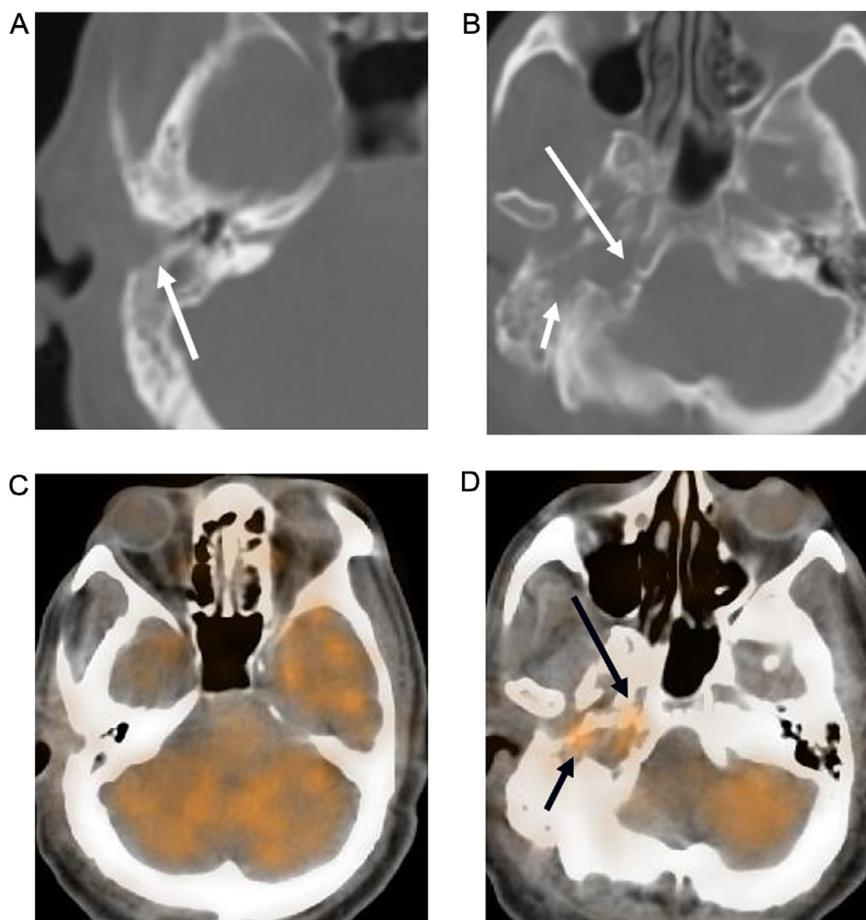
Same patient as Fig. 9. 6 weeks later, follow-up FDG-PET/CT shows residual erosion of the EAC (arrow A) and skull base (arrows B) on the CT images as described in Fig. 9. On the FDG-PET/CT fused images there is no evidence of residual infection at the EAC (C), but there is mild residual uptake at the sites of more inferior skull base erosion (arrows D).
